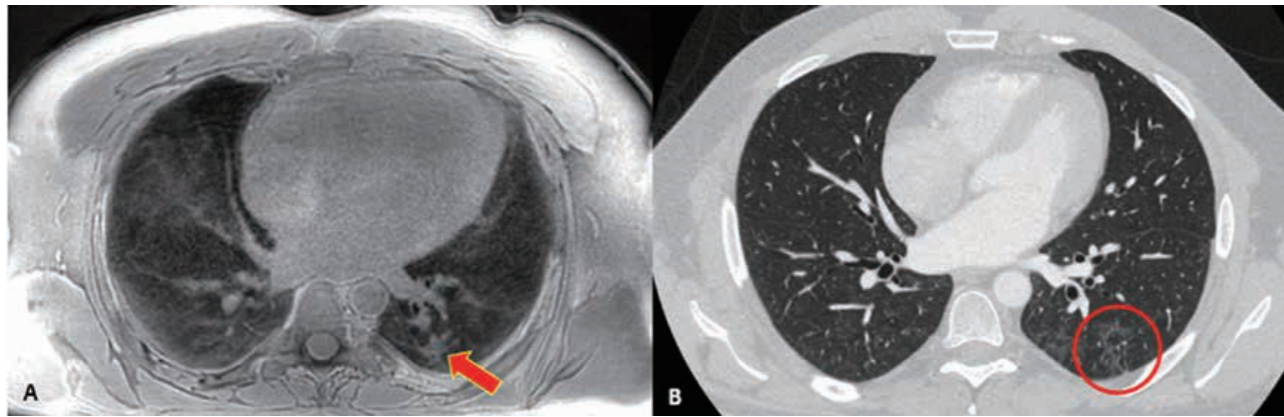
Post hospitalized COVID-19 research participant with ultrashort TE image (A) which demonstrates subtle ground glass opacification and confirmed with CT images (B).
